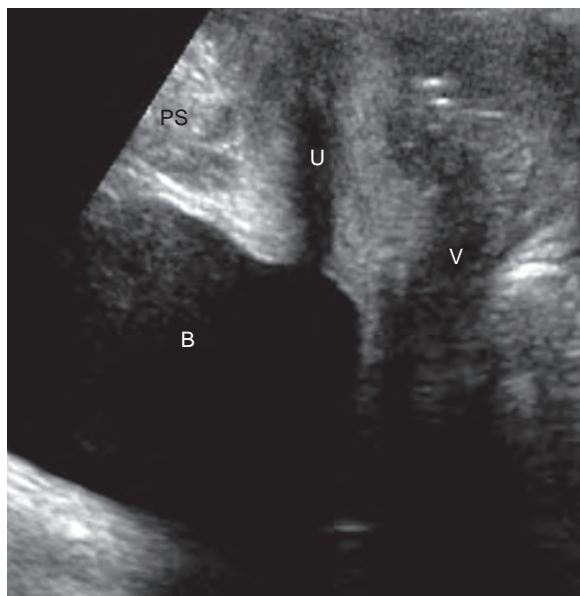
Two-dimensional translabial ultrasound image in the midsagittal plane. B, bladder; PS, pubic symphysis; U, urethra; V, vagina.
